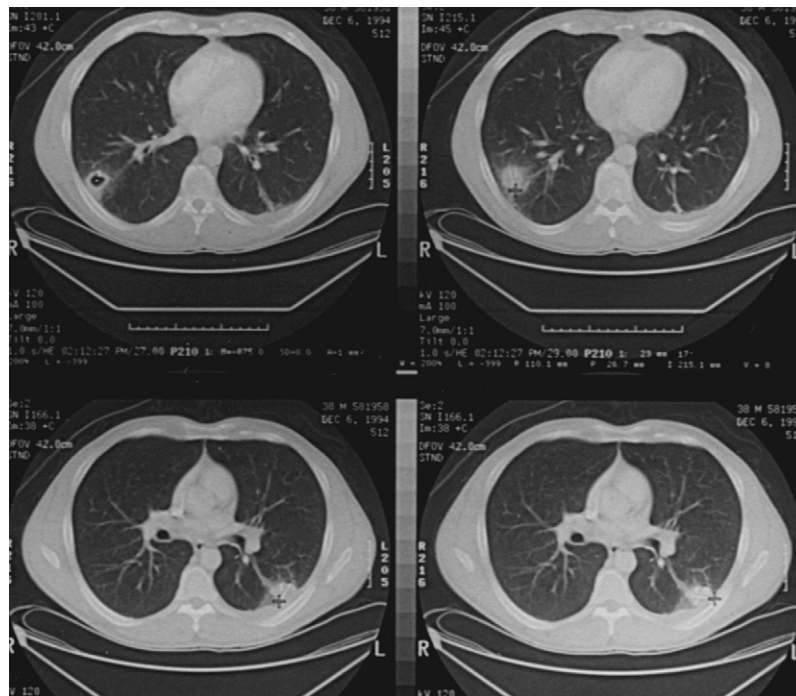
Computed tomography scan of the lungs, revealing the presence of nodules. The right-sided pulmonary nodule is cavitary.
